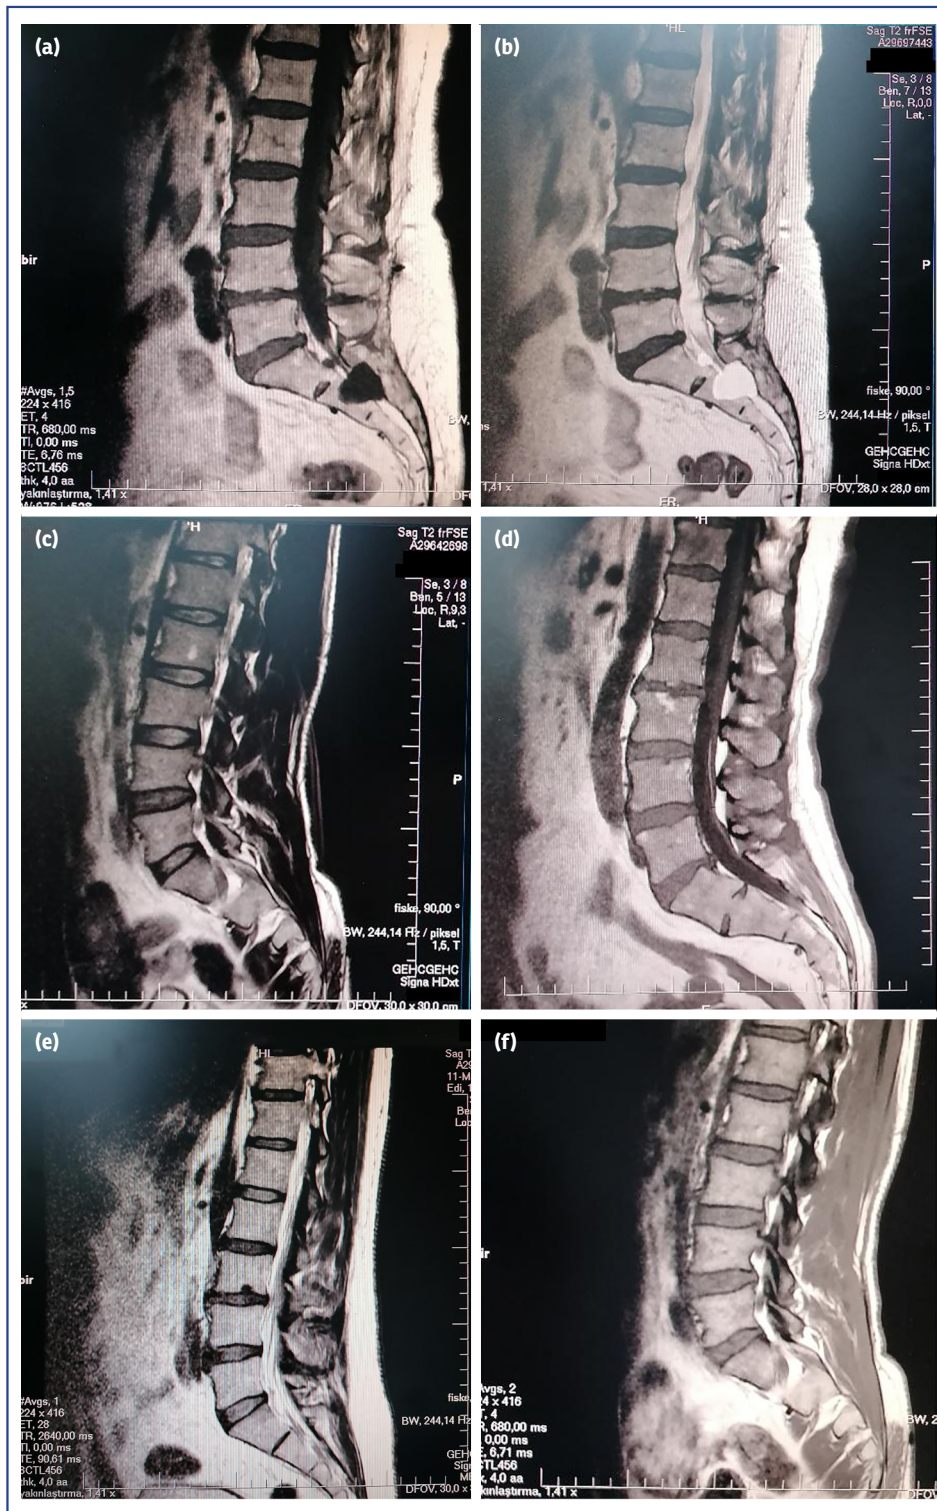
Examples of incidental findings detected in lumbar spinal MRI. (a, b) T1-weighted sagittal images. A Tarlov cyst can be seen at the S2 level (hypointense on T1-weighted image and hyperintense on T2-weighted image). (c, d) T1- and T2-weighted sagittal images, respectively. A hemangioma can be seen at level L2. (e) A Schmorl's node at the lower endplate of L3. (f) A filum terminale fibrolipoma can be seen
